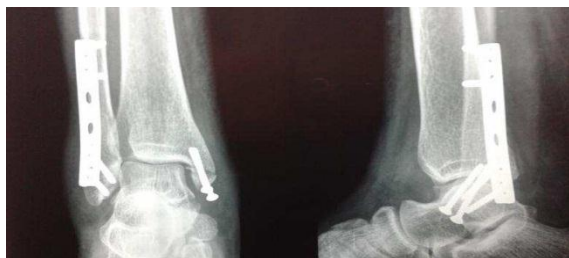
Antero-Posterior and lateral view radiograph at 6-week
